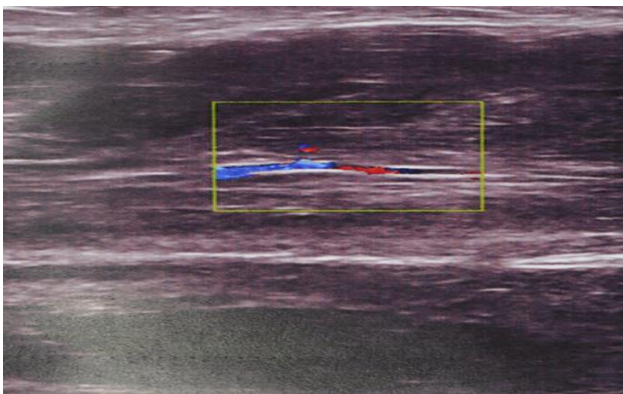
USG doppler image of right lower limb.
